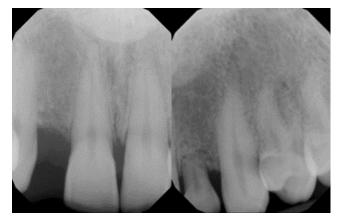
Initial x-ray of Missing Permanent lateral incisor and over-retained primary lateral (#G)
